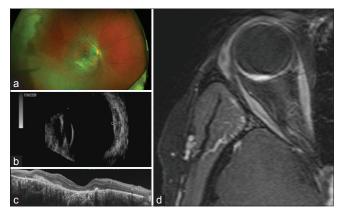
At 10 months follow-up: Optos fundus image shows subretinal pigmentary changes over the treated area (a). B-Scan ultrasound shows significant decrease in tumor height (b). Optical coherence tomography shows complete resolution of retinoschisis and subretinal fluid (c). Magnetic resonance imaging also shows decrease in size of the tumor (d)
